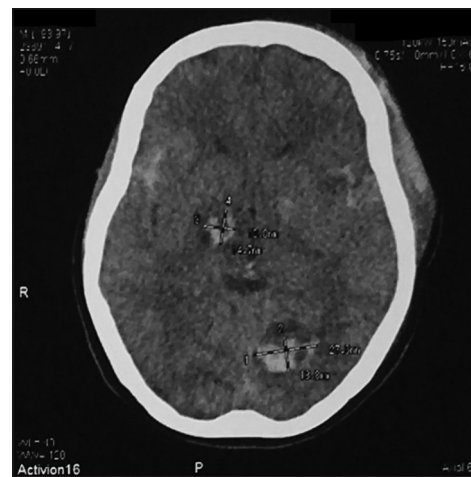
Preoperative head computed tomography scan
